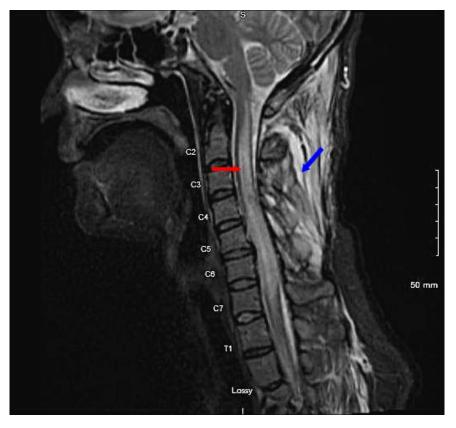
MRI cervical spine showing diffuse cervical spinal cord edema (red arrow) and edematous para-spinous muscles (blue arrow)
